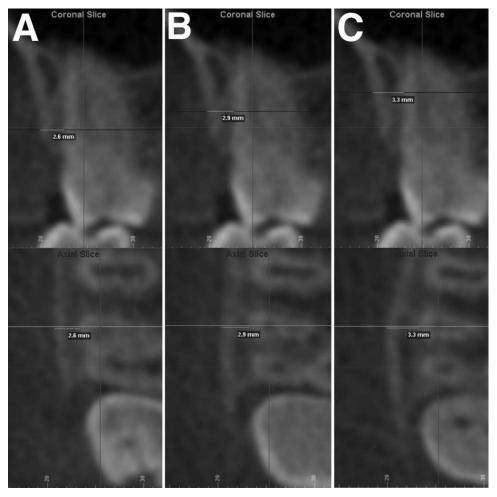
Measurement of buccal alveolar bone thickness on coronal (top) and axial (bottom) CBCT sections: (A) 4 mm, (B) 6 mm, and (C) 8 mm apical to the cementoenamel junction. The left side of each figure segment is the buccal side.
